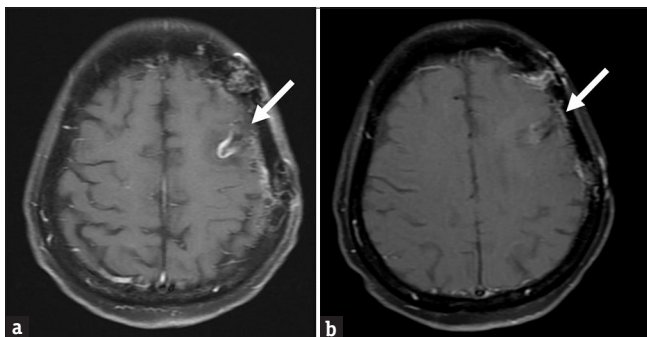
Postoperative magnetic resonance images 3 months (a) and 13 months (b) after the operation reveal focal encephalomalacia in the left frontal lobe with gyral enhancement with no interval variation which favors postoperative change
